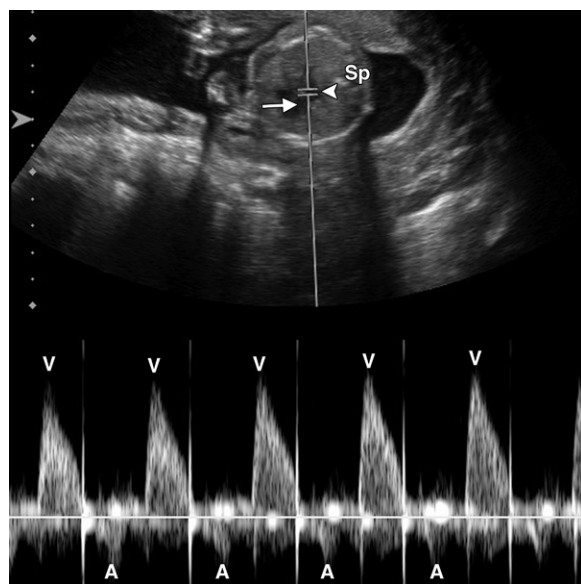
Pulsed Doppler image of heart rate and rhythm. The Doppler sample volume is placed between the left atrium (arrowhead) and left ventricle (arrow). In this example, ventricular contraction (*V*) results in flow out of the ventricle toward the transducer, thus, above the baseline. With atrial contraction (*A*), the blood moves from the atrium to the ventricle and away from the transducer, shown as below the baseline. This allows assessment of atrial and ventricular rates and atrioventricular conduction.
